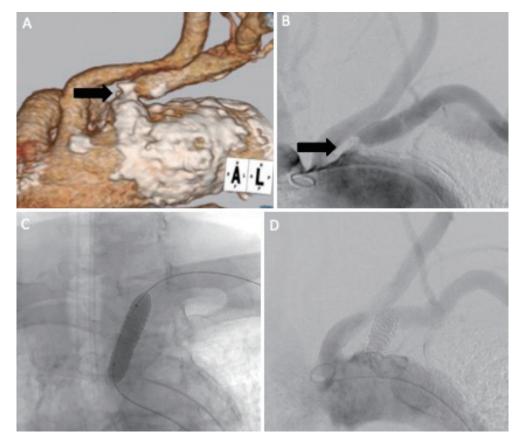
(A) Computed tomography angiography showed heavy stenosis at the beginning of the subclavian artery (*arrow*). (B) Aortography showed stenosis at the beginning of the subclavian artery (*arrow*). (C) The expandable stent balloon was dilated at the site of stenosis. (D) After stent deployment, aortography showed antegrade blood flow to the left VA.
